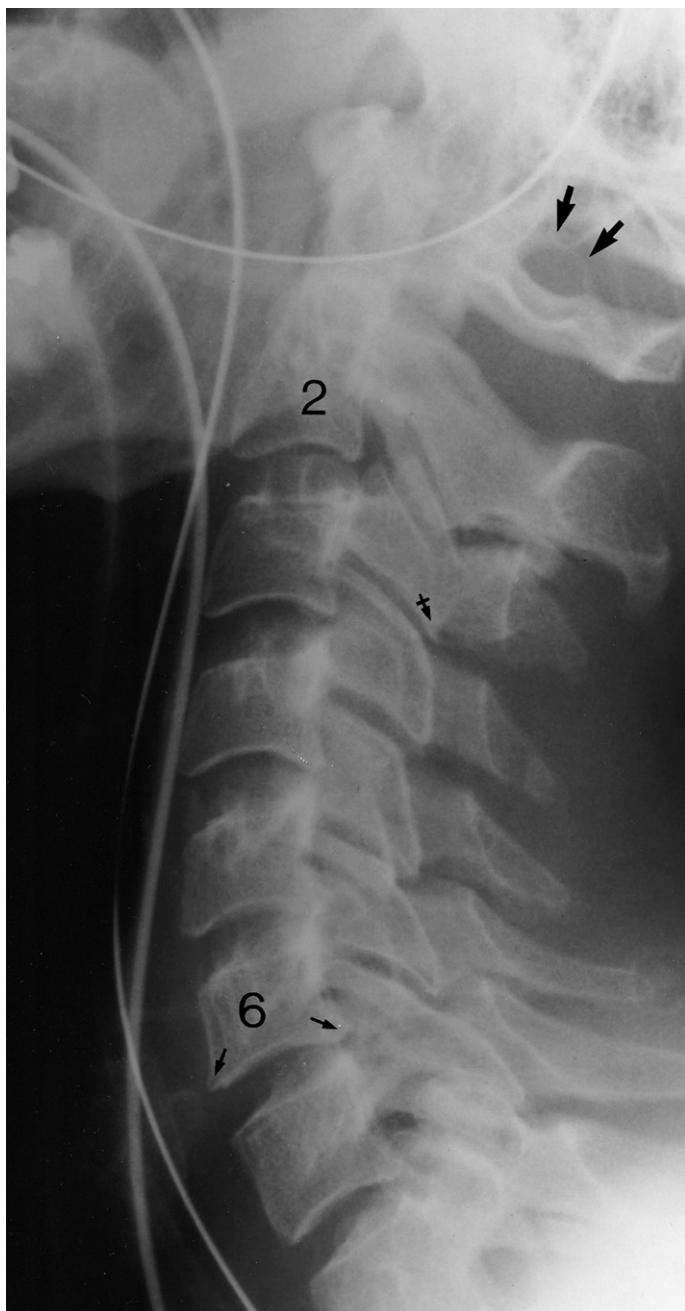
Cervical spine lateral plain X-ray image shows (i) a C1 arcuate foramen on at least one side (large black arrows), (ii) early osteophytic lipping on the antero-inferior and postero-inferior margins of the C6 vertebral body (small arrows), and (iii) early osteophytic lipping of the C3 inferior articular facet (small tailed arrow). An endotracheal tube, a left sided subclavian central venous line and a nasogastric tube are seen.
